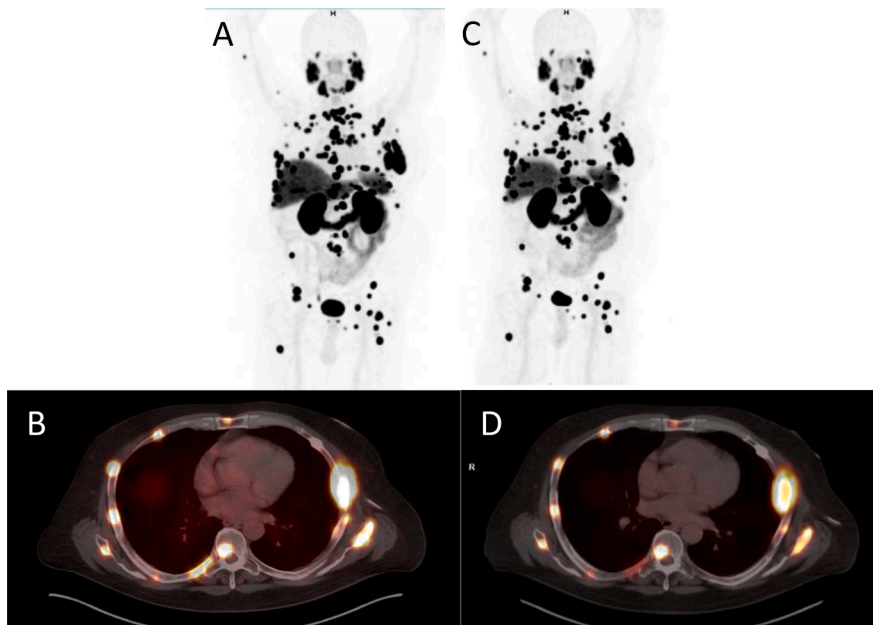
Biochemical recurrence in a 70-year-old patient with a PSA of 27.52ng/mL at the time of the scans. Maximum intensity projection (MIP) (A) and fused PET/MR (B) images show the ⁶⁸Ga-PSMA-cyclotron scan uptake, and the (MIP) (C) and fused PET/MR (D) images show the ⁶⁸Ga-PSMA-generator scan uptake.
